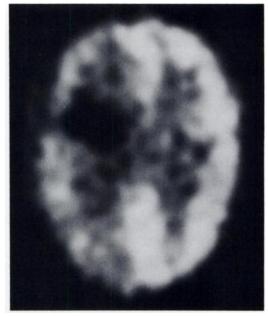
FDG-PET scan, Patient 2. An axial slice shows a large hypometabolic lesion in the right fronto-parietal lobe with no rim of increased deoxyglucose uptake.
